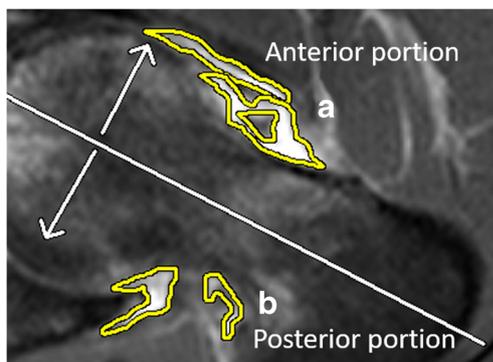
Location of the contrast-enhanced inflamed synovium on contrast-enhanced T1-weighted images with fat suppression (TR/TE: 400/18 ms) was expressed as the ratio of the anterior/posterior areas, i.e., the sum of the outlined areas in the anterior portion (a) divided by the sum in the posterior portion (b) at the mid-central oblique axial slice. In this case, the areas of the anterior and posterior portions were 168 mm² and 113 mm² respectively
